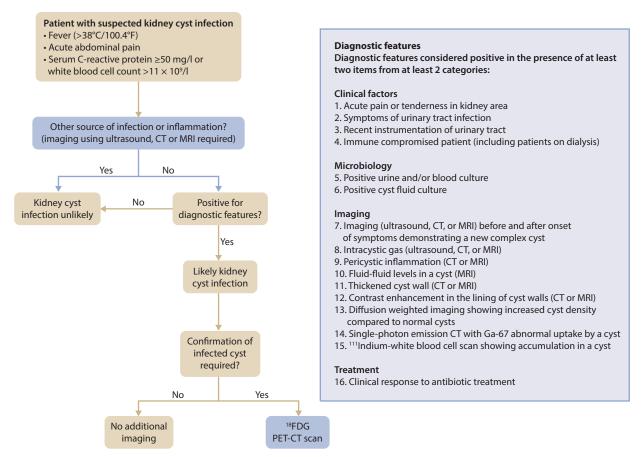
Diagnostic algorithm for an infected kidney cyst in autosomal dominant polycystic kidney disease. CT, computed tomography; ¹⁸FDG PET-CT, positron emission tomography with ¹⁸F-fluorodeoxyglucose integrated with computed tomography; Ga-67, Gallium-67; MRI, magnetic resonance imaging. Adapted from Lantinga *et al.*¹⁵
